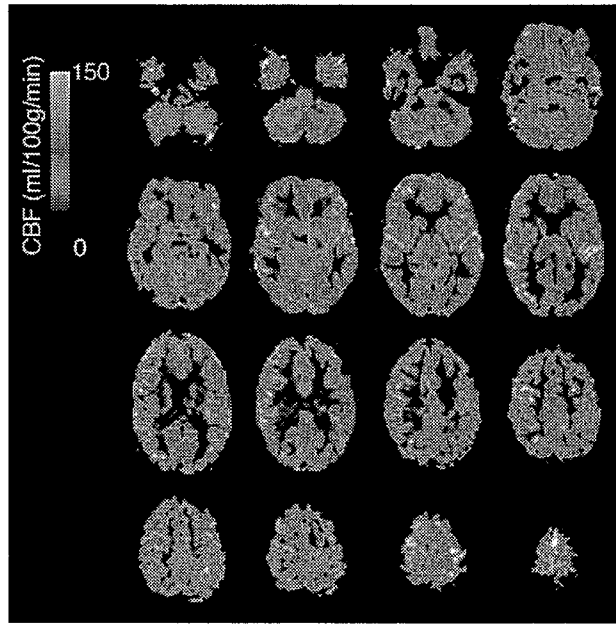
Multislice continuous arterial spin labeling perfusion magnetic resonance imaging obtained at 3 T from a normal volunteer in approximately 10 minutes with spinecho echoplanar imaging. *Abbreviation:* CBF, cerebral blood flow.
